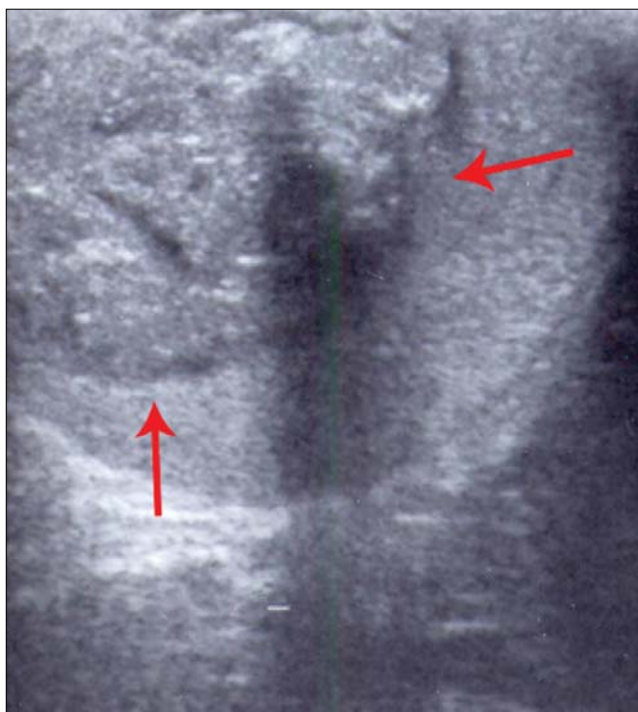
Ultrasonographic appearance of the testis and the mass. Red arrows show the intraparenchymal mass with hypoechoic center.
